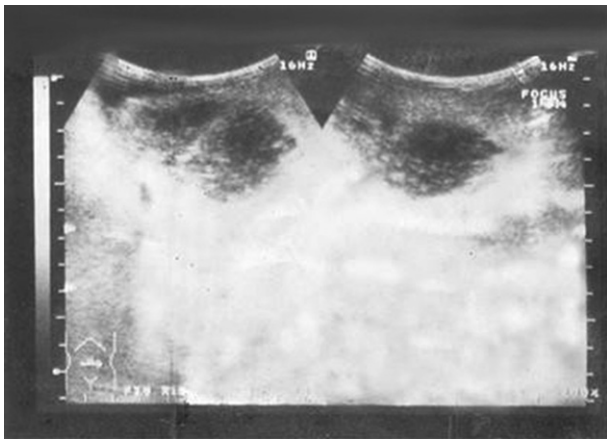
Ultrasonogram showing hematoma under the liver capsule.
